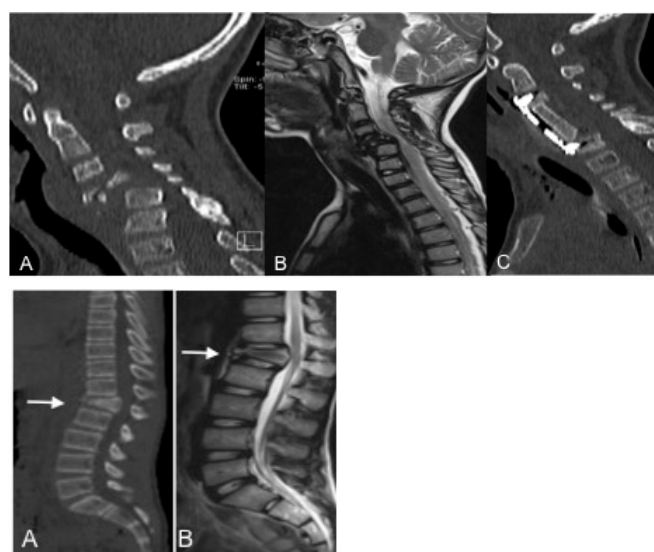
A 5 year-old boy patient with fracture of C4 and C5 after motor vehicle accident. (A) Sagittal computerized tomography image, (B) Sagittal T2 weight magnetic resonance image, (C) Postoperative sagittal computerized tomography who anterior approach of the C4 and C5 corpectomy with plate and screw.
